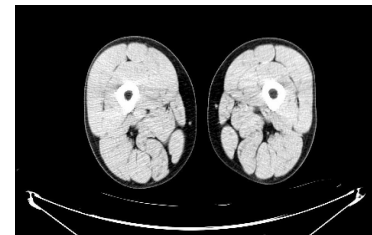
A two-dimensional CT image of mid-thigh axial slice. Note that as tissue density increases, image lightens.
